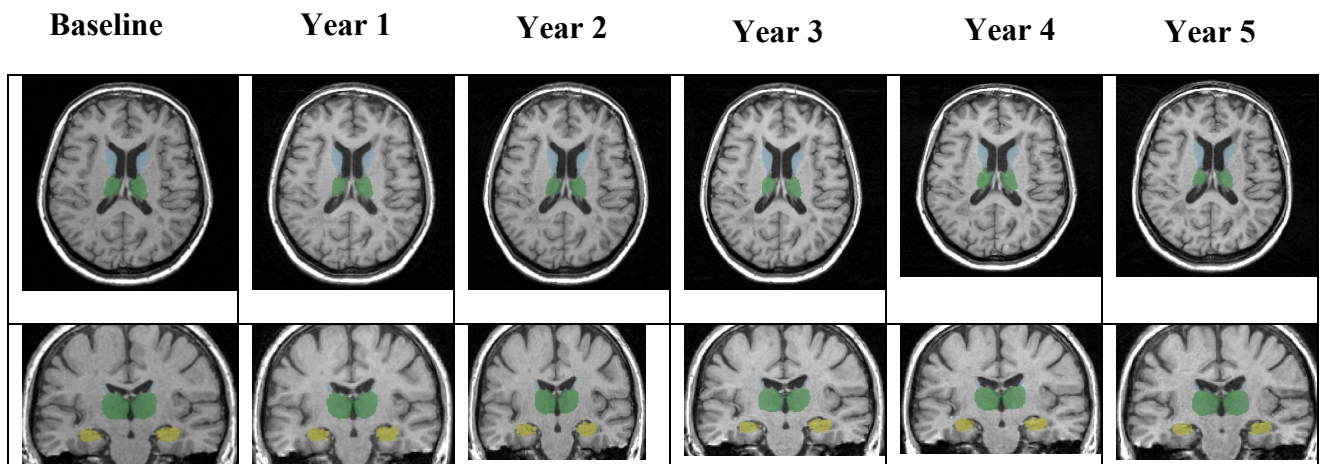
Deep gray matter volume (DGM) changes of representative relapsing-remitting multiple sclerosis patient on serial yearly 3D-T1-SPGR MRI scans over 5 years. The highest DGM volume decline occurred in the hippocampus (yellow color) and in the thalamus (green color). The baseline to year changes for various time points were noticed for hippocampus: year 1: -1.8%, year 2: -2.7%, year 3: -3.7%, year 4: -4.9%, year 5: -6.2%, whereas the changes for thalamus were, as follows: year 1: -1.6%, year 2: -2.6%, year 3: -3.5%, year 4: -5.1%, year 5: -6.1%. Substantial DGM volume decline was observed in other structures like caudate, putamen, nucleus accumbens and amygdala.
